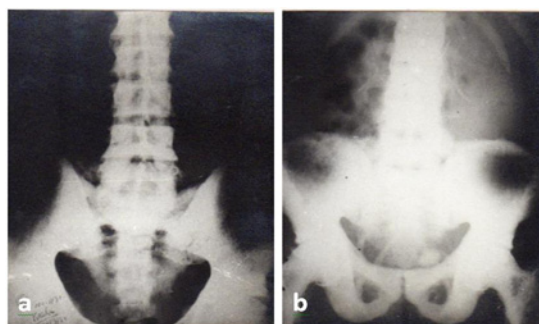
Radiographs lumbo-dorsal spines or vertebrae of subjects having moderate (a) and very severe (b) skeletal fluorosis showing diverse progressive changes in spines or vertebrae markedly sclerotic with irregular new bone formation, considerable lipping, and osteophytosis. Interspirous and other spinal ligaments also showed calcification in severe skeletal fluorosis (b).
